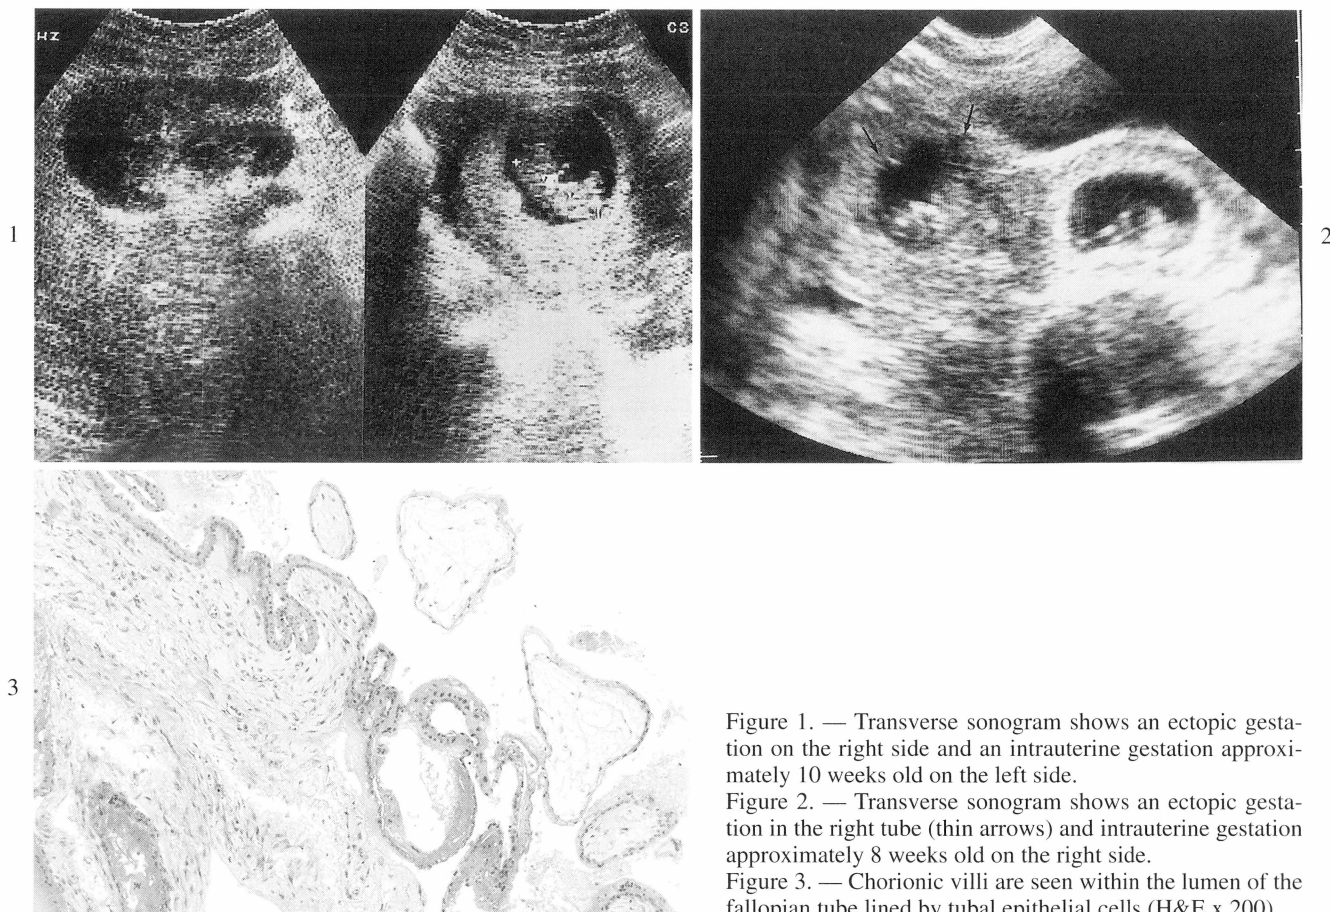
Transverse sonogram shows an ectopic gestation on the right side and an intrauterine gestation approximately 10 weeks old on the left side.
